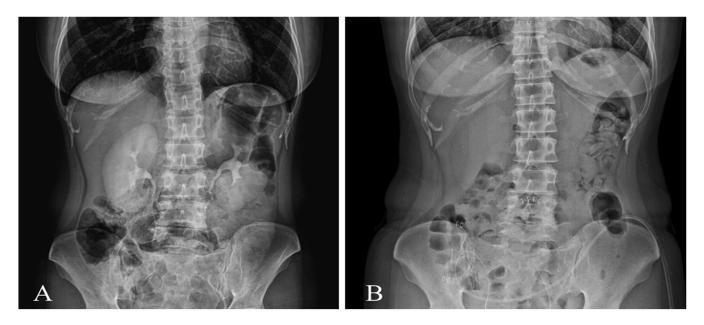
Simple abdominal radiography. (A) An internal hernia of the sigmoid colon was detected early during the visit to the emergency room. (B) After surgery, the adhesive band had been removed and the colon and small bowel returned to their original positions.
